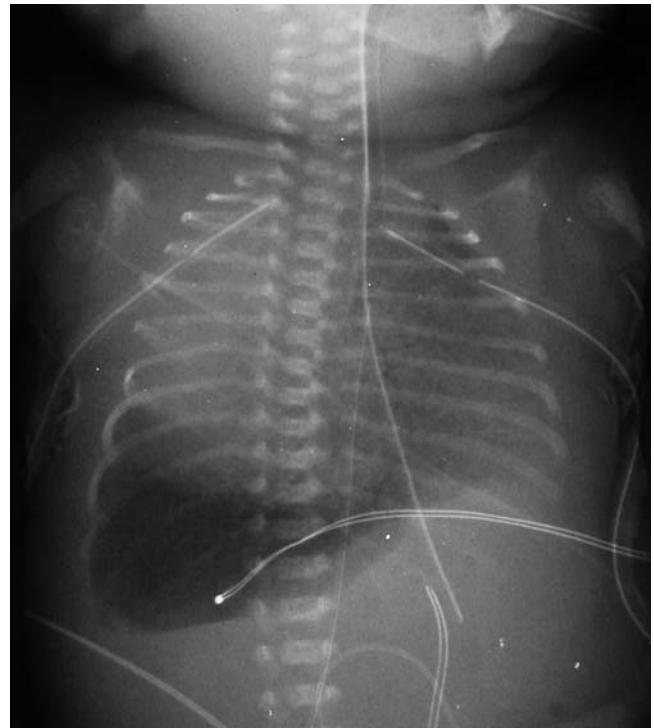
Congenital pulmonary myofibroblastic tumor. Chest X-ray. This neonate was delivered at 28 weeks gestation and found to have hydrops and respiratory distress at birth. Chest X-ray showed a large mass in the right upper lung field, causing flattening of the right diaphragm, mediastinal shift, and displacement of the heart. He had rapid deterioration despite ventilatory support and died less than 24 h after delivery (Courtesy of Dr. S. Galatzan, Doctors Regional Medical Center, Corpus Christi, TX).
